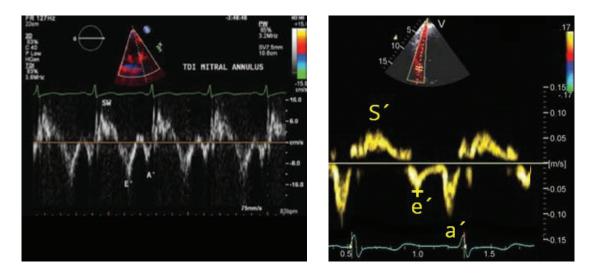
Tissue Doppler trace of lateral E' and septal e'.
